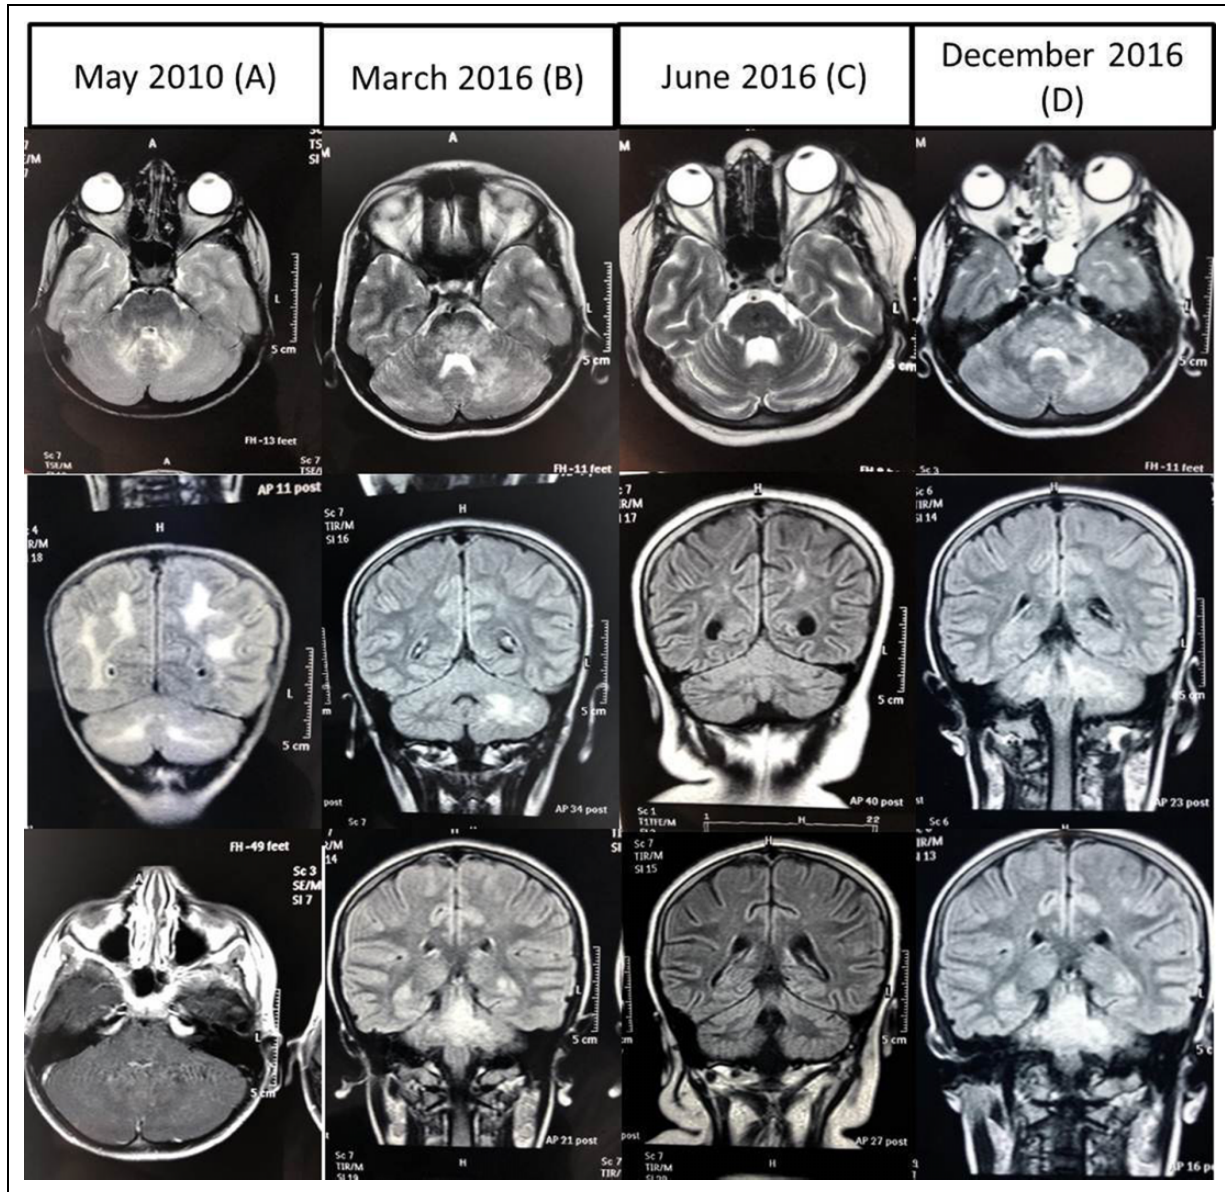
A, Magnetic resonance imaging (MRI) of the brain suggested altered signal intensities, hyperintense on T2 in subcortical and deep white matter over parieto-occipital and bilateral cerebellar region. B, The MRI of the brain suggested white matter signal changes in bilateral cerebellar hemispheres, cerebellar peduncles, pons, and midbrain. Similar changes in left thalamus, adjacent posterior limb of internal capsule, parahippocampal gyrus, and parietal regions on both sides. Small changes in the left frontoparietal subcortical white matter. C, Significant decrease in hyperintensities as compared to (C), but not totally cleared. D, Reappearance of lesions and patchy involvement of pons, midbrain, cerebellar peduncles, and cerebellum.
